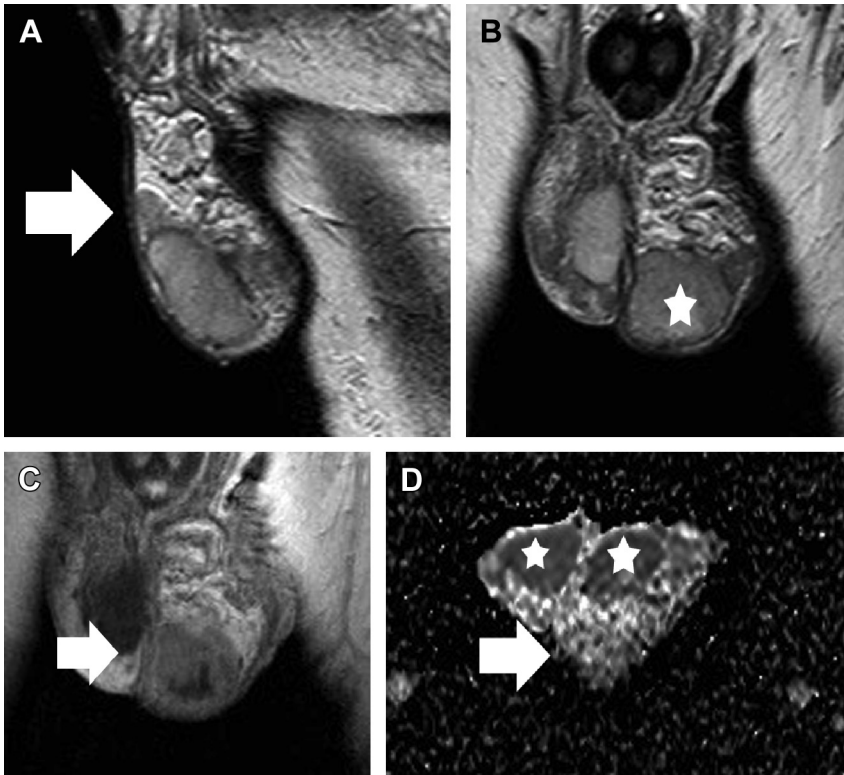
Left epididymo-orchitis in a 71-year-old man. (A) Sagittal and (B) coronal T2-weighted images show enlargement and hypointensity of both the left epididymis (*arrow*, A) and the testis (*asterisk*, B). (C) Coronal DCE image depicts heterogeneous lesion enhancement (*arrow*). (D) The ADC values of the left epididymis (*arrow*) are $1.53 \times 10^{-3} \text{ mm}^2/\text{s}$ and that of the ipsilateral testis (*asterisk*) $0.94 \times 10^{-3} \text{ mm}^2/\text{s}$, (right testis: $1.05 \times 10^{-3} \text{ mm}^2/\text{s}$, *asterisk*).
